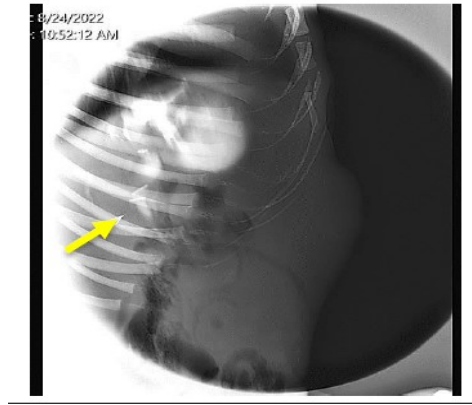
Radiographic image shows the free passage of bile into the duodenal cavity when used Titanium clips (Yellow-arrow)
